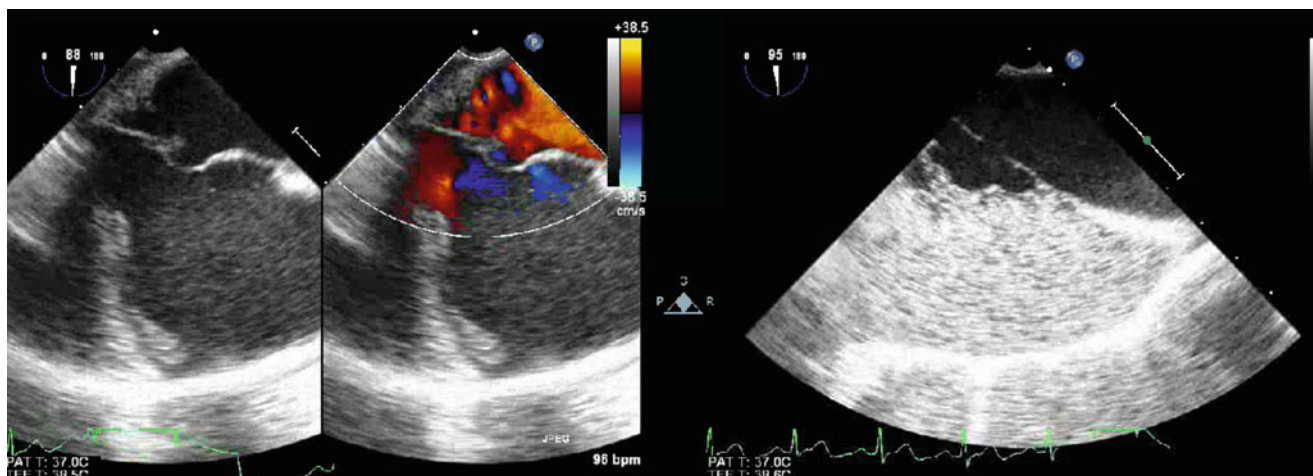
Images demonstrate an aneurysm of the interatrial septum as shown by two-dimensional imaging (*left panel*), color flow mapping (*middle panel*), and contrast echocardiography (*right panel*). Injection
